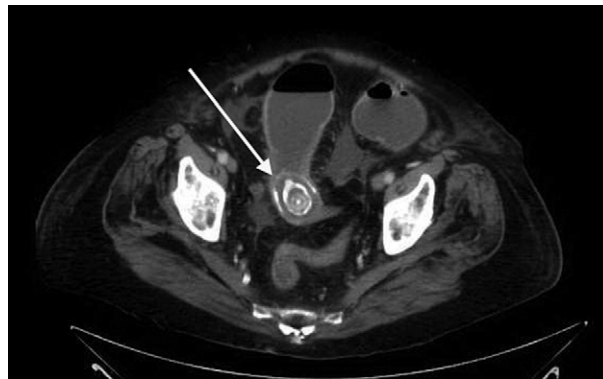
Present abdominal CT image demonstrating a large stone within the sigmoid colon (arrow).
